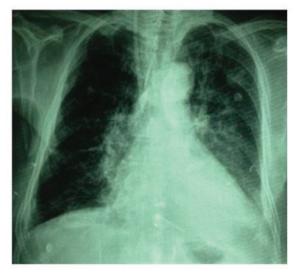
Chest X-ray antero-posterior view showing the regression of the lung mass.
